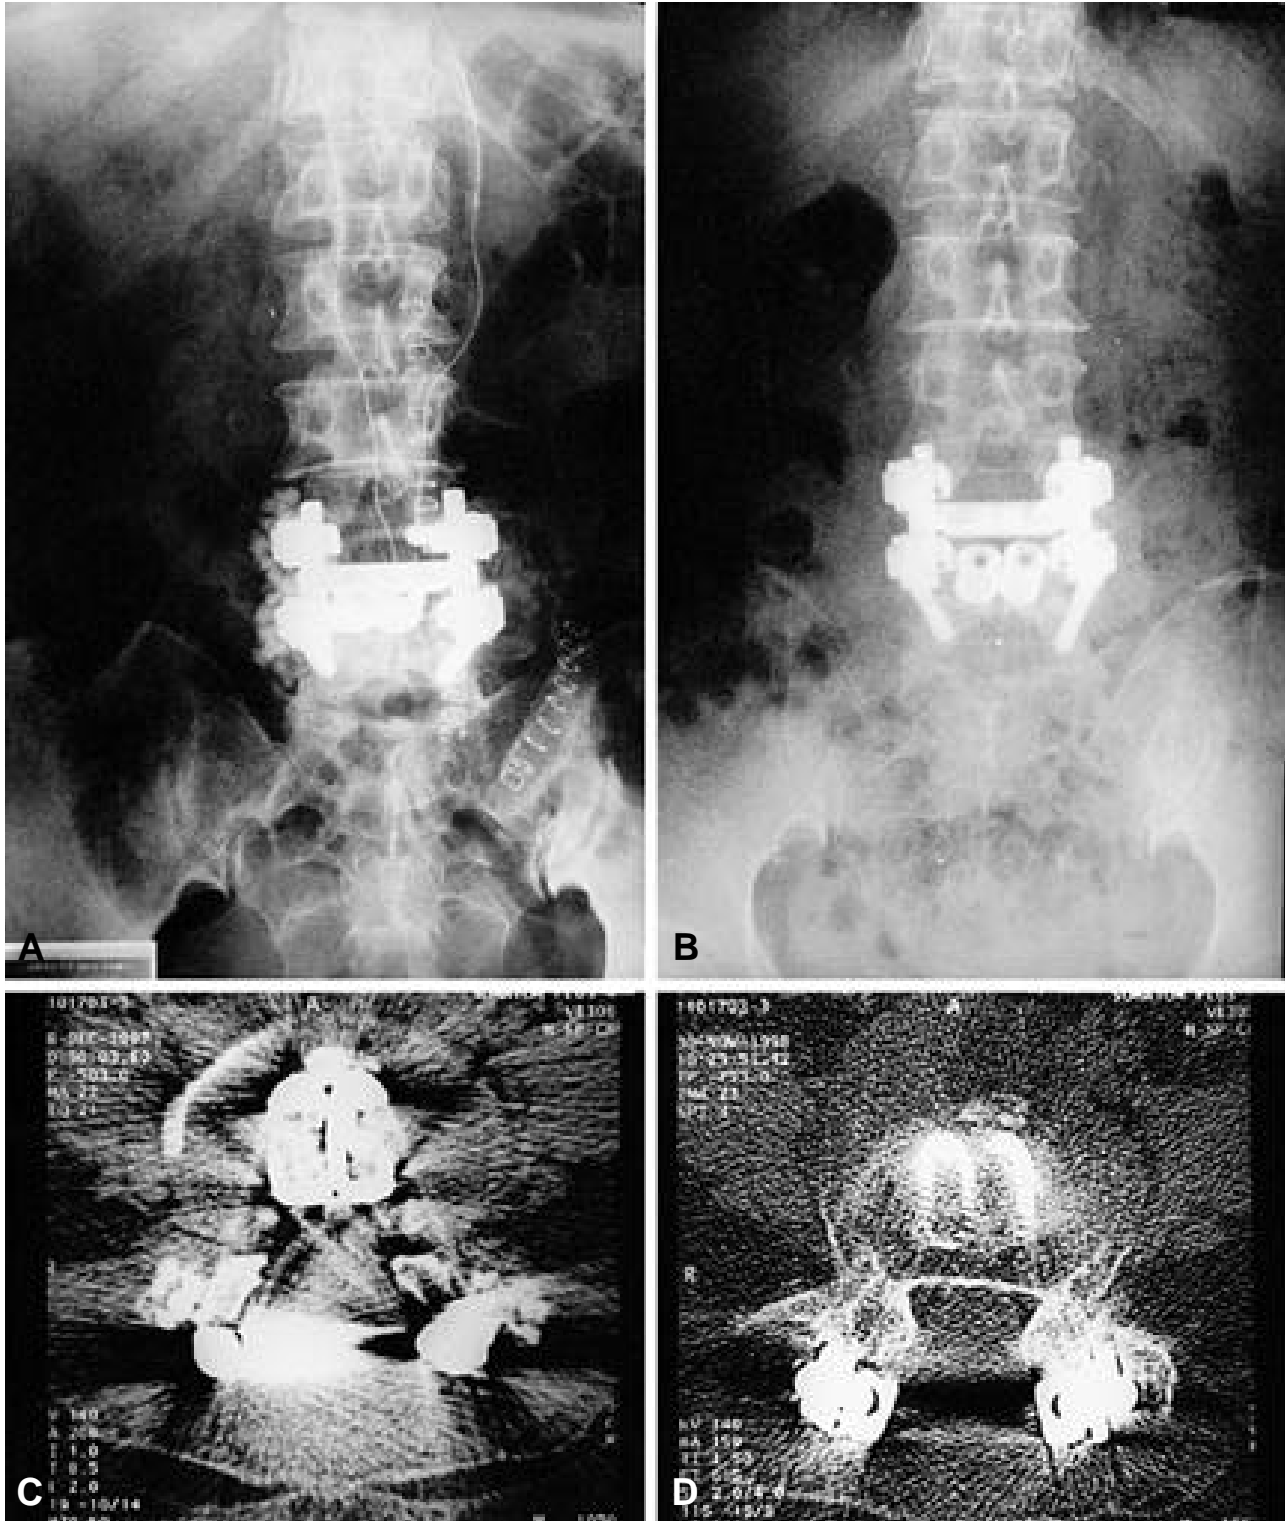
Postoperative roentgenogram
